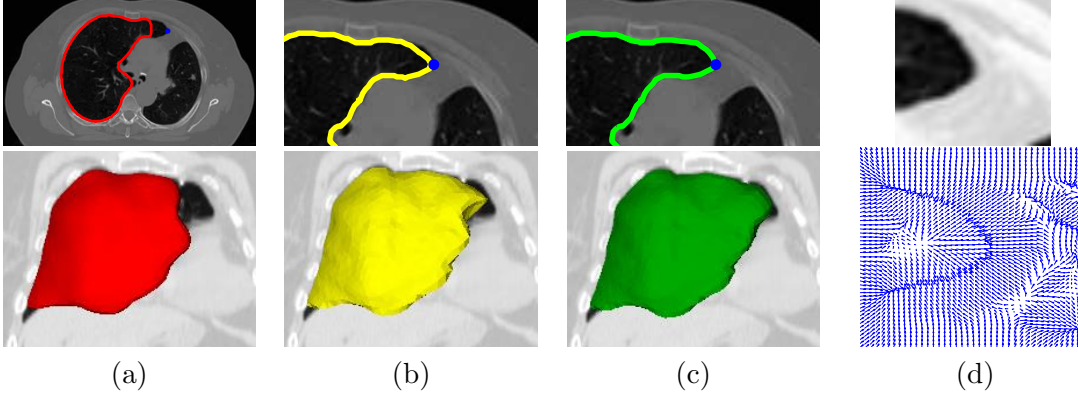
Example of interactive CT lung segmentation. (a) shows the initial segmentation (red) and user specified control point (blue); (b) shows the editing result (yellow) with only geometric constraint by control point; (c) shows the editing result (green) with both geometric constraint and image force F_C ; (d) shows an axial image patch and the force field F_C .
